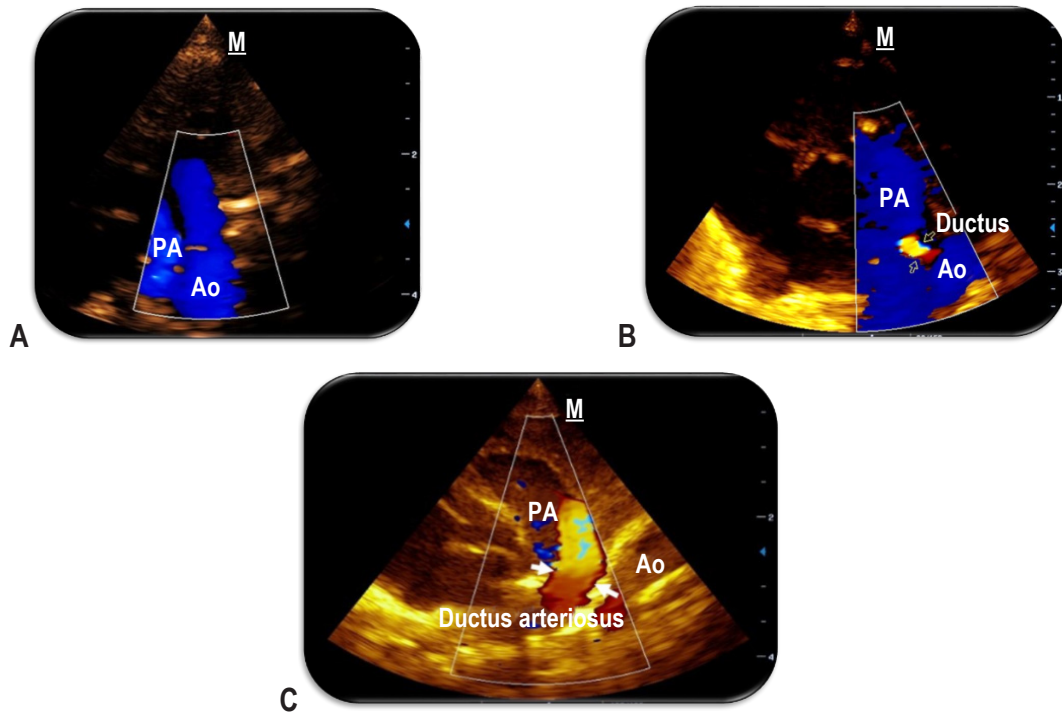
High left parasternal view. Ao = aorta; PA = pulmonary artery. A: Ductus arteriosus closed; B: Narrow ductus arteriosus (1mm) with left-to-right blood flow; C: Wide ductus arteriosus (3.1mm) with left-to-right blood flow. Source: personal archive of author AMRS.
